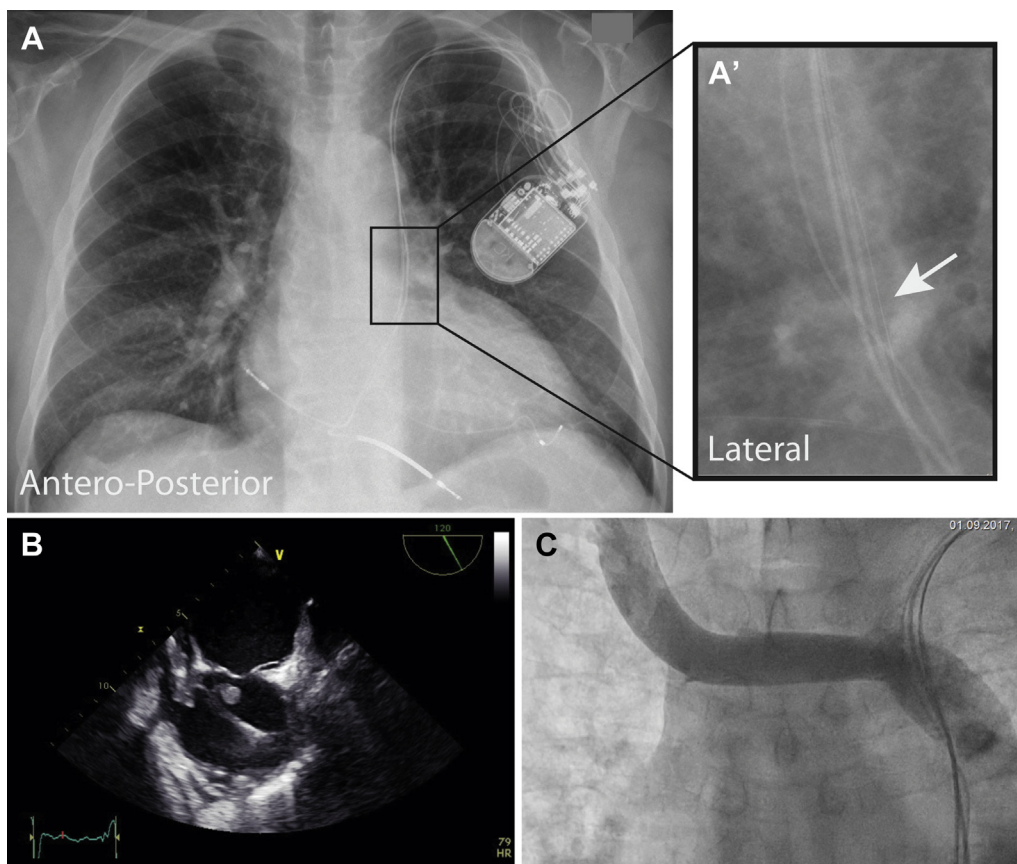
Transvenous lead extraction in a patient with type II persistent left superior vena cava (PLSVC). A: Chest radiograph showing the cardiac resynchronization therapy defibrillator device, implanted through the PLSVC. Inset (A'): Lateral chest radiograph excerpt with externalization of the Riata lead (arrow). B: Transesophageal echocardiogram with a large mobile vegetation 10×16 mm on a lead traversing the right atrium. C: Phlebography from the right jugular vein, depicting the absence of a right superior vena cava (type II PLSVC).
